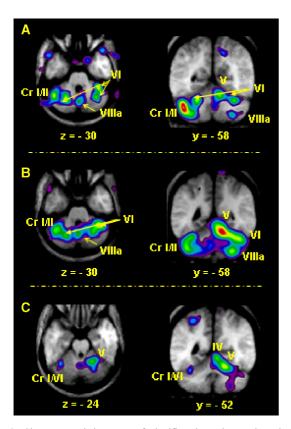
Shows *t* statistic maps of significantly active regions in the cerebellum for the BLK1 vs. ISO contrast (panel A); the BLK1 vs. PER contrast (panel B) and the ISO vs. PER contrast (panel C). PET data are coregistered with the average MRI of the 12 subjects and slice levels are given in the standardized space of Talairach and Tournoux. Images are thresholded at $t > \pm 2.5$ to allow visualization of regions of activation below the statistical threshold of $t > \pm 3.5$ that may be of interest.
